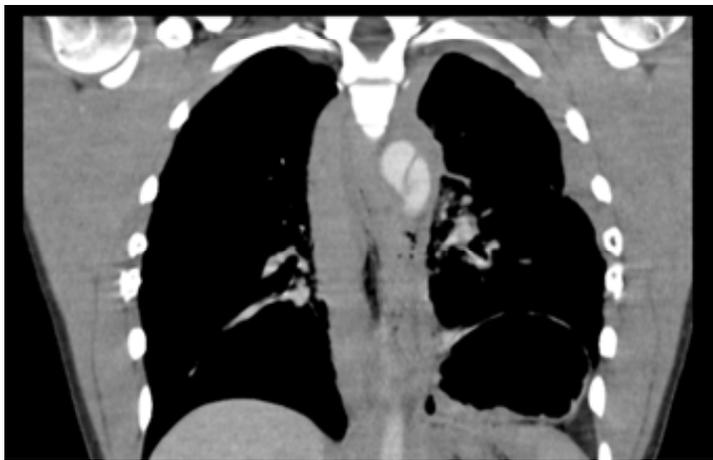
CT scan images on hospital admission
